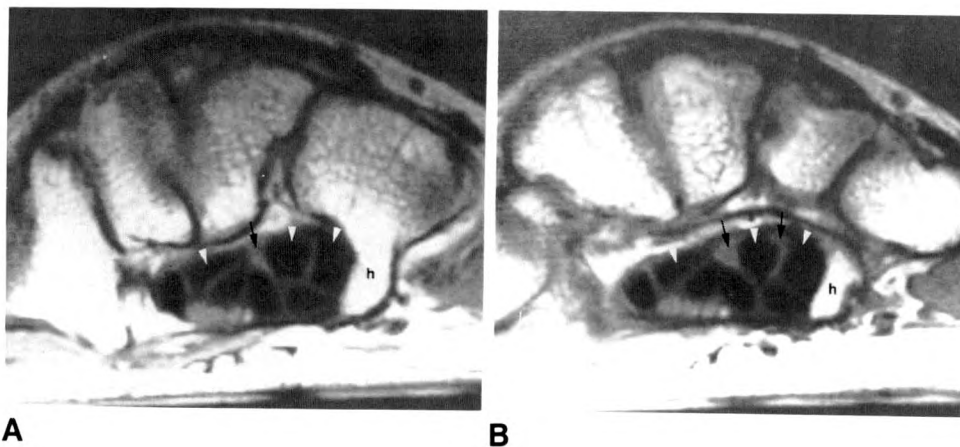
Anomalous proximal origin of lumbrical muscles. Proximal (A) and distal (B) axial MR images (TR 600, TE 25) through hook of hamate (h) show lumbrical muscle tissue (arrows) originating in carpal tunnel of normal volunteer as far proximally as hook of hamate. Deep flexor tendons (arrow-heads). Left wrist viewed toward elbow with palm down.
